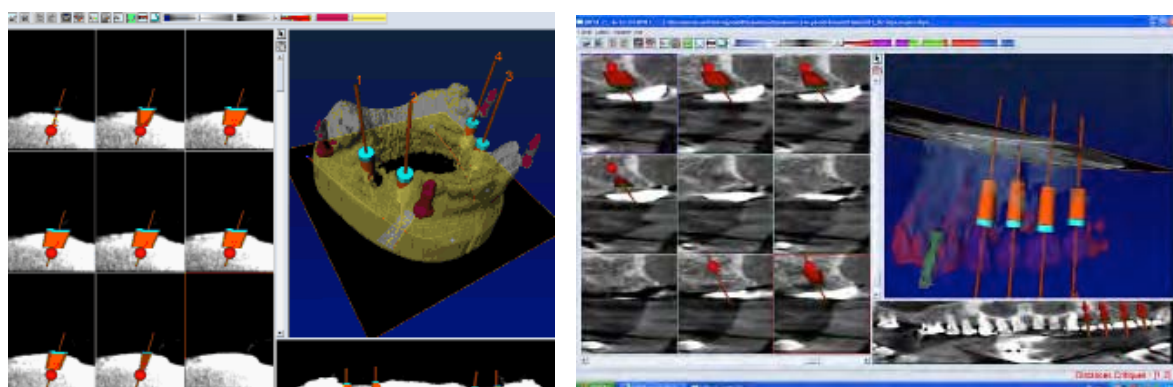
Planning and CAD/CAM phase. The CT images were imported into the planning software and the implants were virtually inserted.
